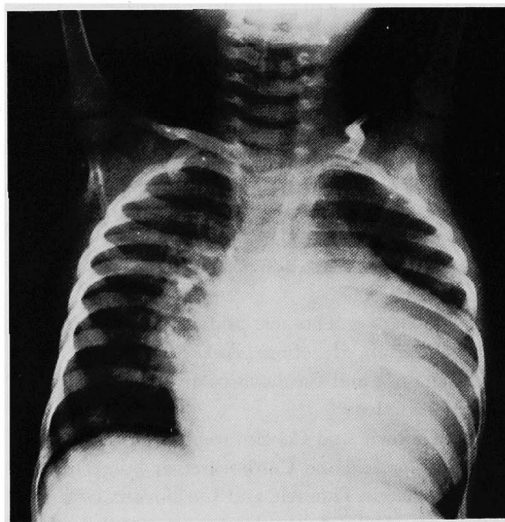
Preoperative chest X-ray showing global enlargement of the cardiac silhouette.
